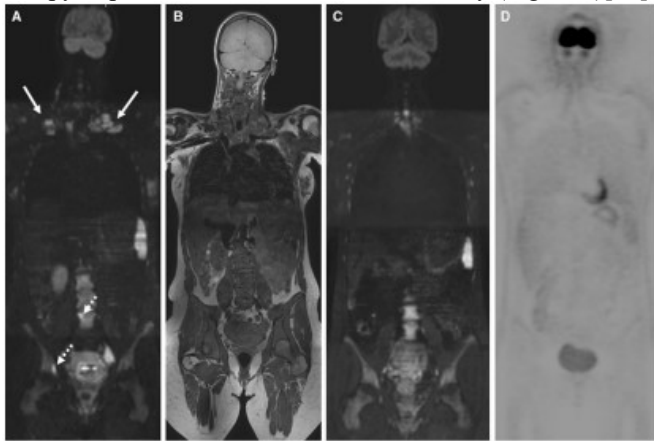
During non-invasive prenatal testing, the unintentional discovery of Hodgkin lymphoma in a pregnant woman. Two bright bone marrow lesions at the right acetabulum and the fourth lumbar vertebral body correspond to diffuse hypo-intensity at (B) the T1-weighted sequence, which shows bright and enlarged lymphadenopathies in the bilateral base of the neck (arrows). After two rounds of treatment, an interim whole-body diffusion-weighted MRI reveals complete response. The end-of-treatment hybrid positron emission tomography/CT showed full response after delivery.
